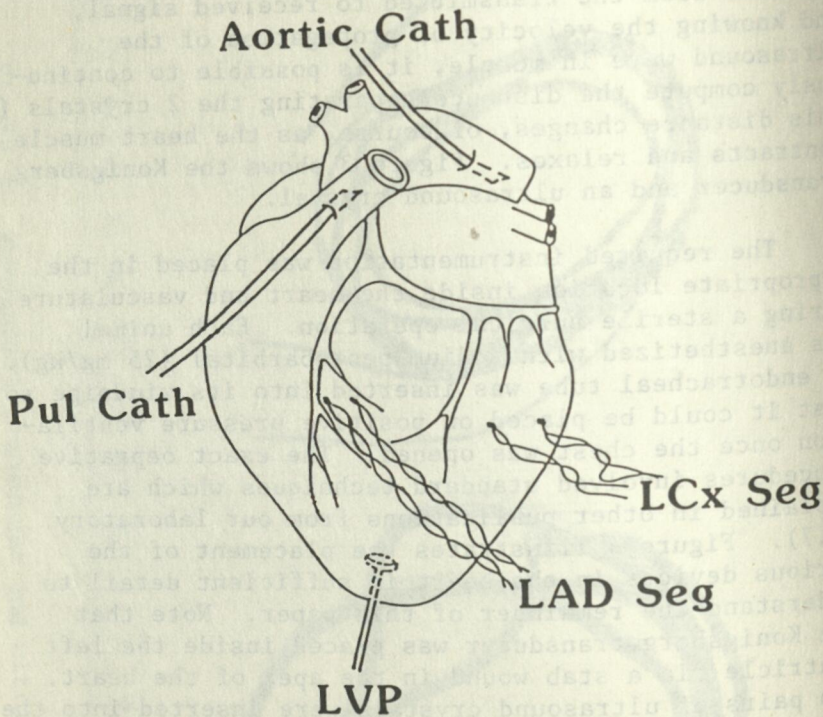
Instrumentation placement. Pul Cath, pulmonary catheter for drug injection; Aortic cath, aortic catheter for arterial pressure measurement; LVP, left ventricular pressure measured by a Konigsberg transducer; LAD Seg and LCx Seg, pairs of ultrasound piezoelectric crystals for measuring myocardial segment lengths.
